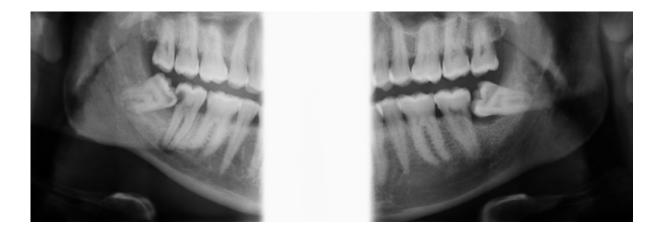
Dental panoramic radiograph of mandibular mesioangularly impacted third molars in a patient at low risk of caries but who exhibits bilateral DSC in the adjacent second molars.
